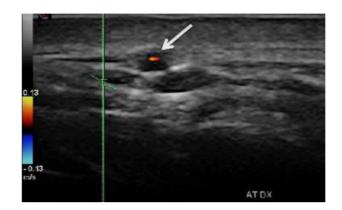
Duplex ultrasound of the right temporal artery–transverse view. The white arrow indicates a "halo" sign (a dark/hypoechoic circumferential wall thickening around the lumen), which represents arterial wall edema ^[19].
